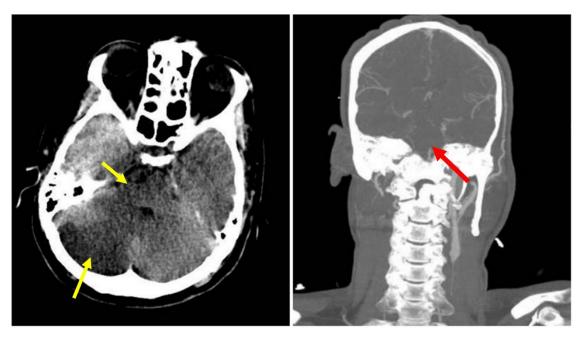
Pre-thrombectomy brain CT scan and CT angiography. The yellow arrows indicate the infarct zone, and the red arrow indicates the basilar artery occlusion.
